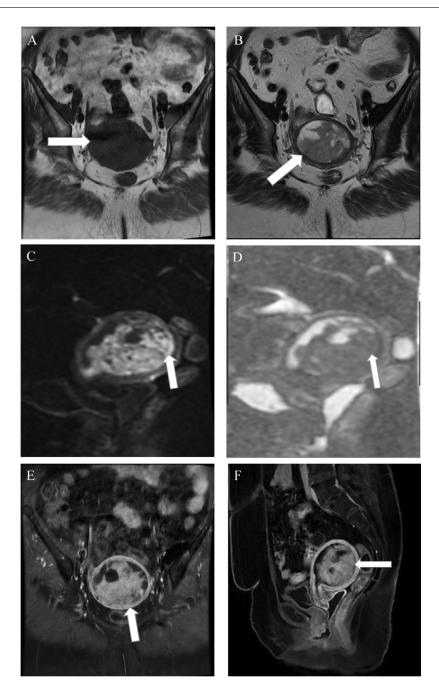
The axial precontrast T1-weighted (A) and T2-weighted (B) MRI images demonstrate a heterogeneous mass (arrows) centered within the uterus. Within the mass, there are several regions with limited diffusion (arrows, (C, D) showing strong signal on DWI (C) and matching low signal on the ADC map (D). On postcontrast axial (E) and sagittal (F) T1-weighted fat-saturated images, the lesion shows heterogeneously enhanced (arrow).
